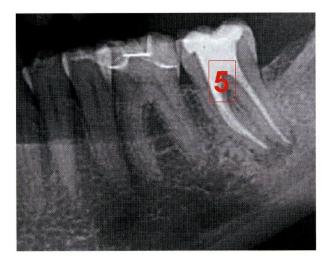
Tooth 37 that looks satisfactorily filled on the X-ray with a high dispersal of toxins.
